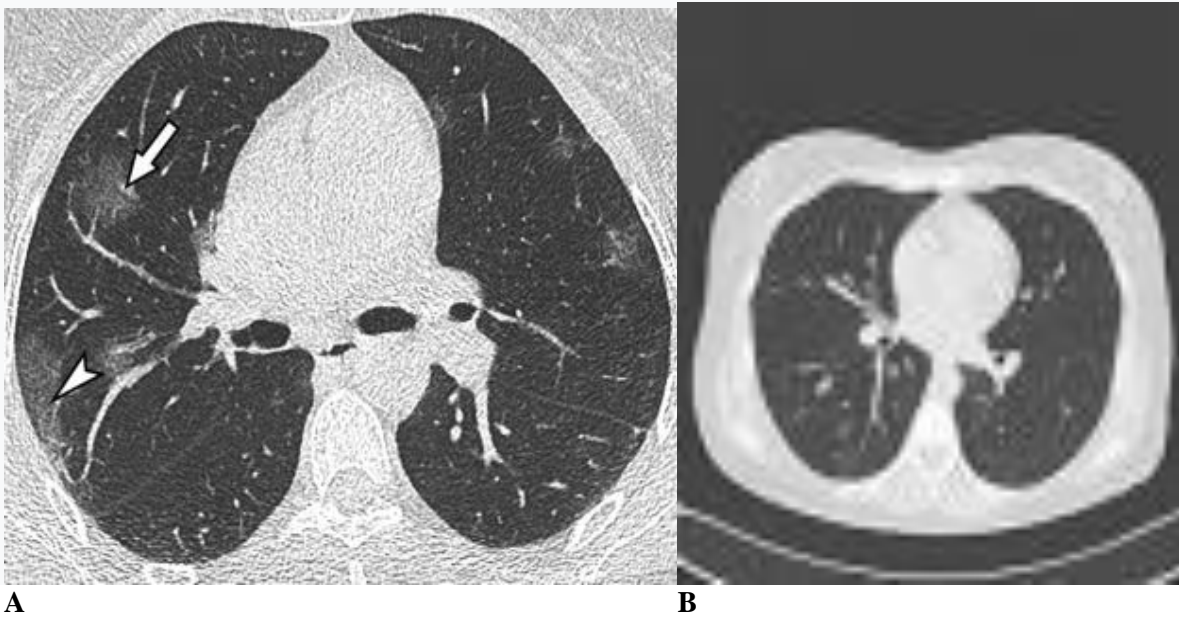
A- CT finding with verified pneumonia with areas of ground glass opacities; B- CT finding after regression of lung changes
